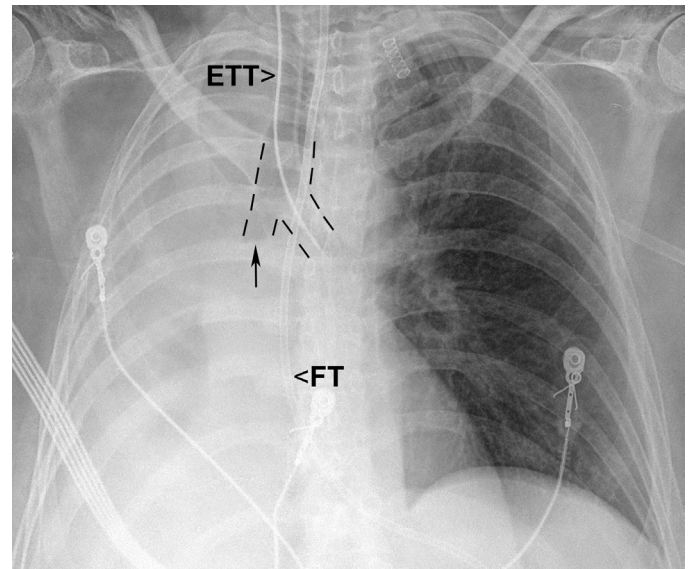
■ Anteroposterior (AP) chest x-ray. Left MS (main stem) bronchus intubation with the collapse of the right lower lobe (RLL) and right middle lobe (RML) and rightward shift of the mediastinum. Arrow marks the “cutoff sign” of the distal right main stem bronchus. Note that with RML collapse, the hemidiaphragm and right atrial border are not seen as there is no longer an air interface. ETT, endotracheal tube; FT, feeding tube.
